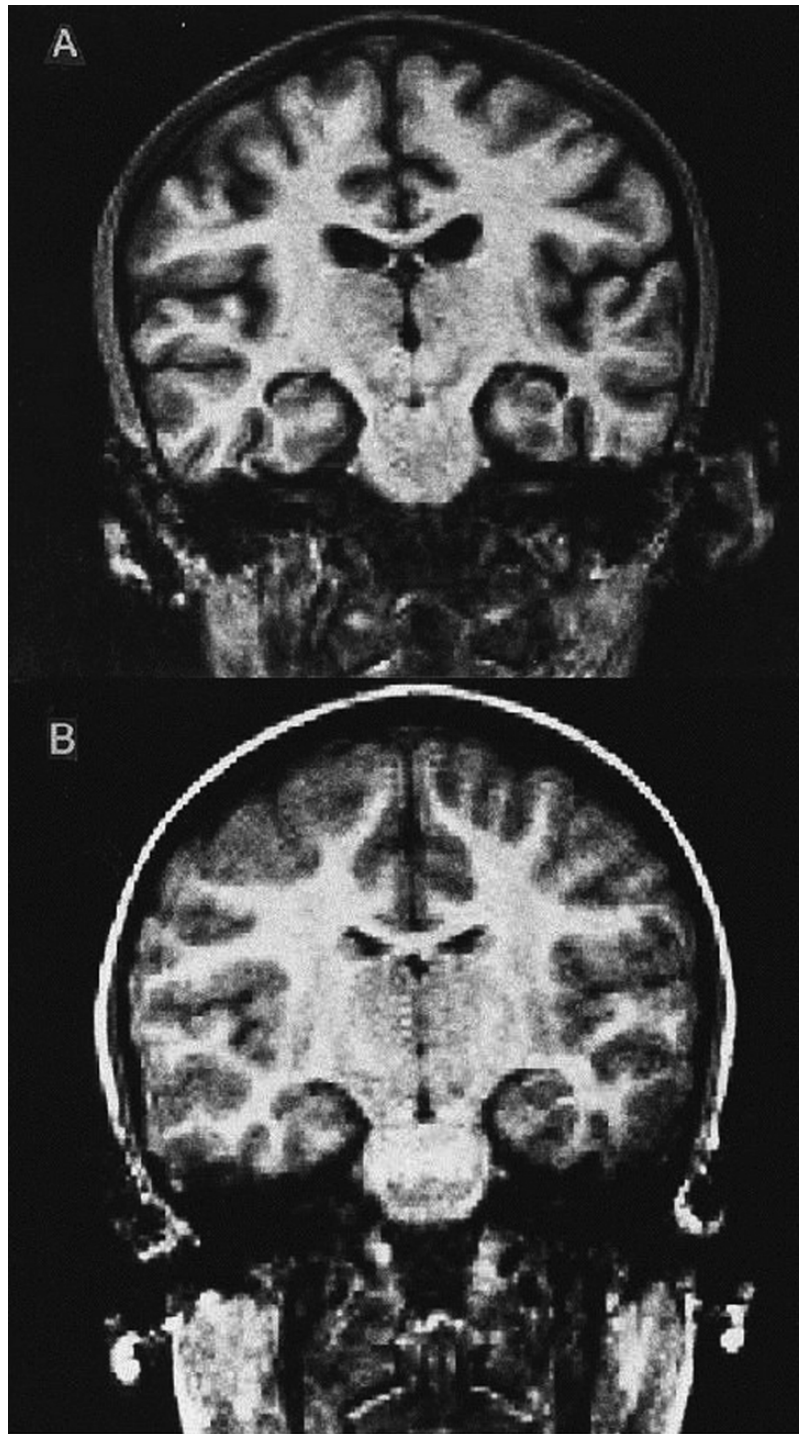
Coronal MRI scan of an 11-year-old patient with anorexia nervosa (A) compared with that of an 11-year-old healthy control subject (B). A Sulcal enlargement and marked dilation of the third and lateral ventricles. B Normal anatomy at the same level. Reprinted from reference (158), with permission from Elsevier.
